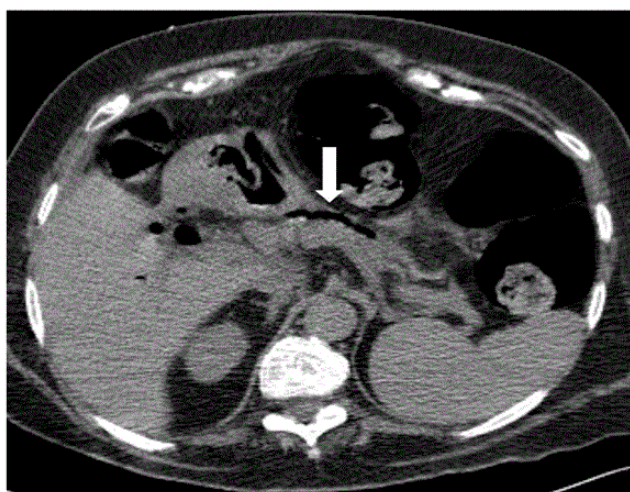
Type C retroperitoneal perforation. CT demonstrated free air anterior to the pancreas in the lesser sac.
